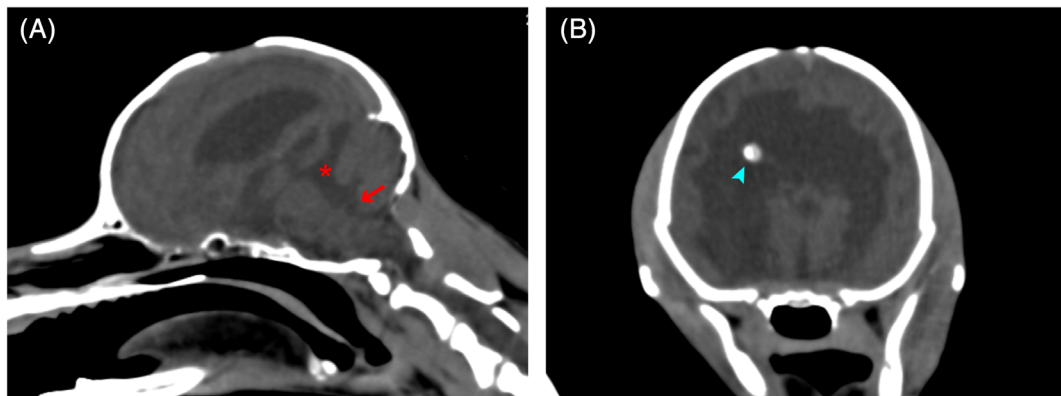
Multiplanar reconstruction images of follow-up computed tomography (CT; A, sagittal; B, transverse). The supracollicular fluid accumulation (A, asterisk) and dilation of the 4th ventricle (A, arrow) are apparent, but the cerebral parenchyma is expanded. The shunt tube is visible on the transverse image (B, blue arrowhead)
